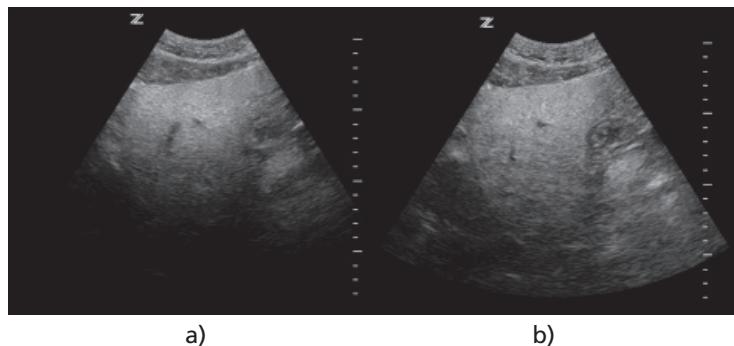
Ultrasonic images of a difficult to image liver: (a) Imaged at a sound speed of 1540 m/s. (b) Imaged at a sound speed of 1490 m/s and +2 dB digital gain to improve the signal-to-noise ratio. Note the differences in penetration, contrast resolution, boundary clarity, and detail resolution seen in image (b) compared with image (a). These images were obtained with a curved transducer (C5-2) at a centre frequency of 3.0 MHz and depth of 18 cm.
